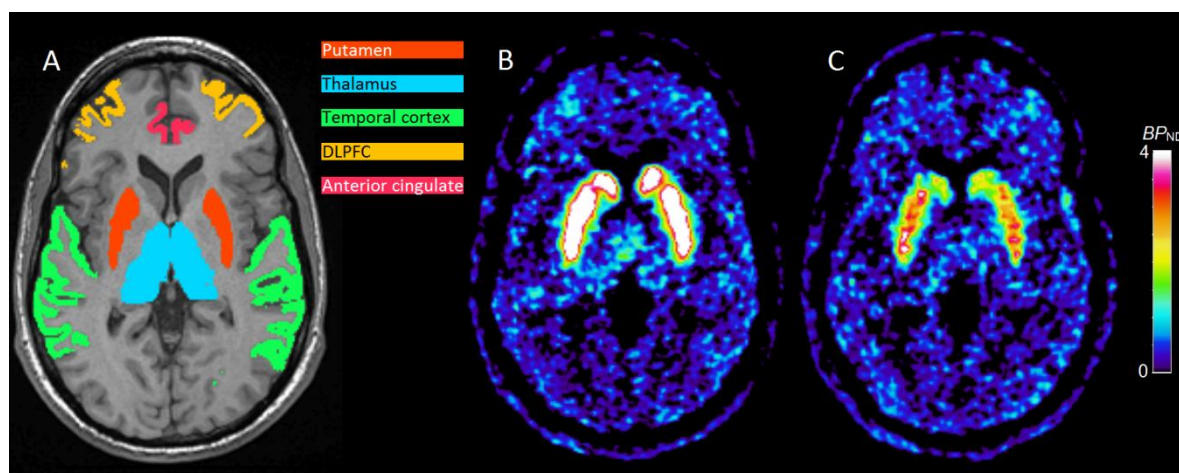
MRI and parametric PET images for one subject. A) MRI with regions of interest overlaid B) [¹¹C]raclopride binding at baseline C) [¹¹C]raclopride binding after pretreatment with quetiapine. DLPFC, dorsolateral prefrontal cortex.
